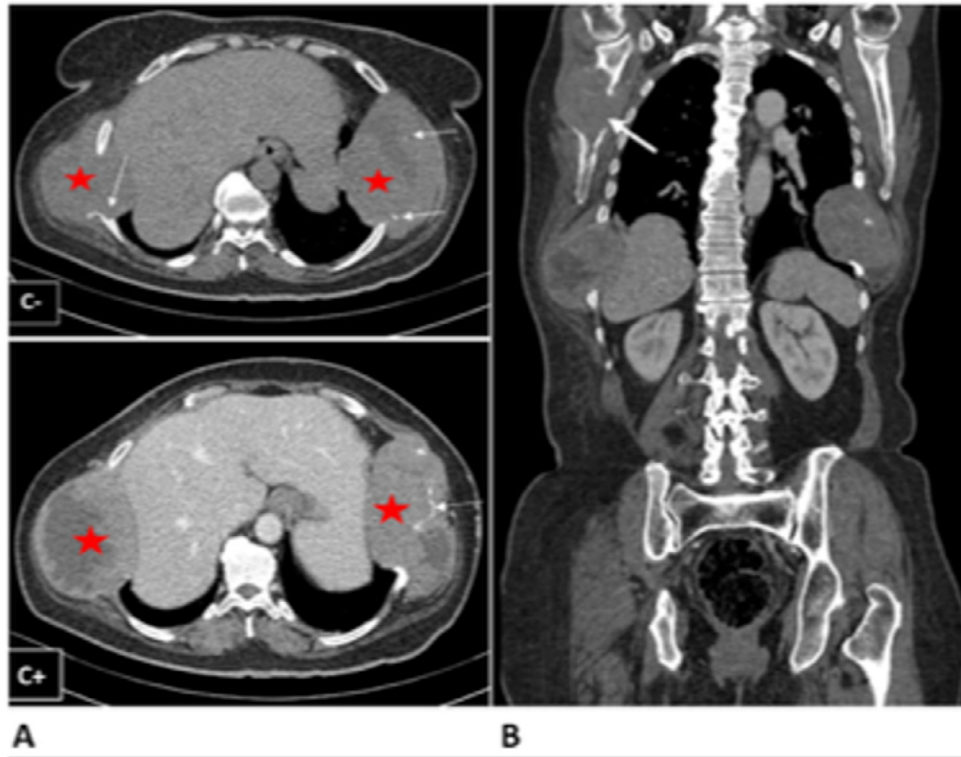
(A) Axial CT (before [C-] and after [C+] injection): bilateral basithoracic masses (red star) heterogeneous tissue containing calcifications (white arrow) and necrotic areas with bilateral lysis of the 9th rib. (B) Coronal CT scan showing a right scapular mass with cortical lysis (white arrow).
